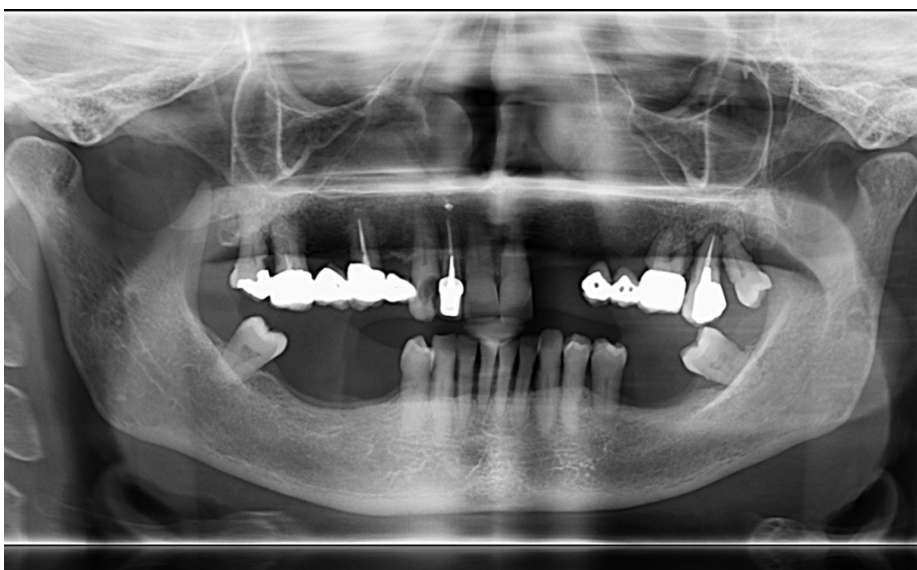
Orthopantomography of the patient at the baseline before implant treatment.
